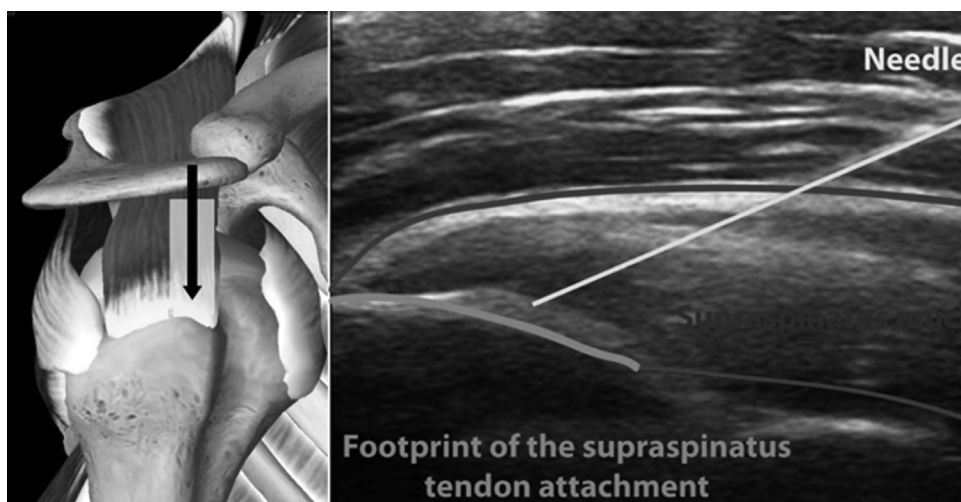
An injection under ultrasound of the supraspinatus tendon at its footprint, demonstrating the ability of the technology to demonstrate the high-quality visualization of the tendon. (Reproduced with permission from The Centeno-Schultz clinic.)
